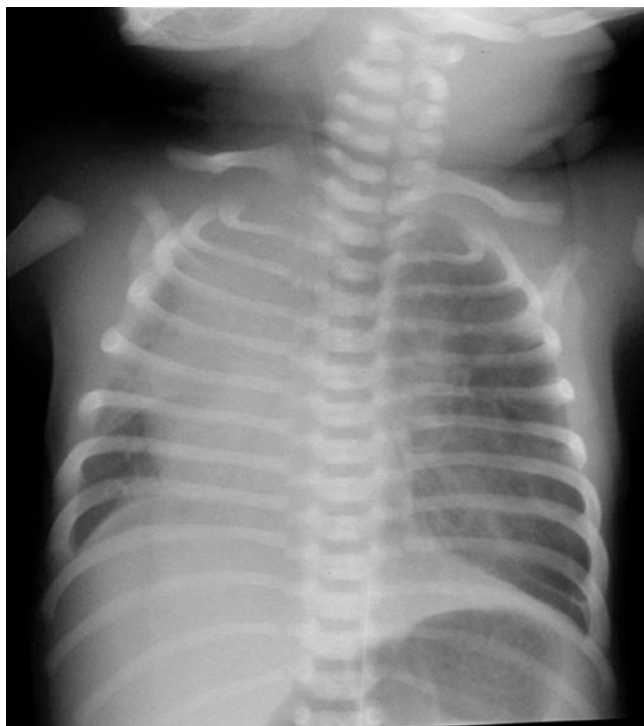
Congenital lobar emphysema. Chest radiograph with hyperinflation of the left chest and displacement of the cardiac silhouette toward the right chest. A large gastric air bubble is present
